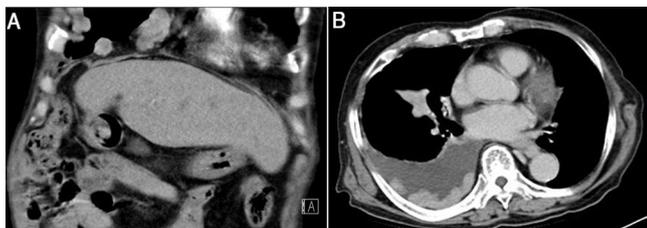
A and B: In A abdominal computed tomography showing no local recurrence over the liver, and in B chest computed tomography showing multiple right pleural masses with moderate pleural effusion.
